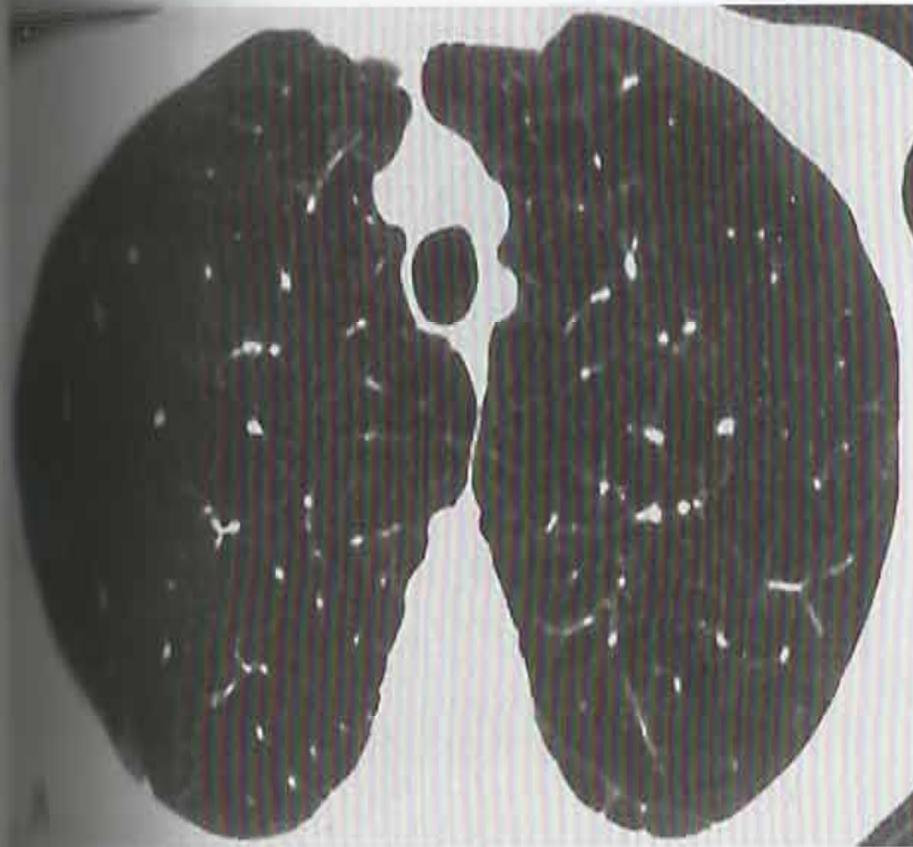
Panlobular emphysema in two patients. A: On HRCT, lung volumes are increased, the lungs appear lucent, and the size of pulmonary vessels is decreased. Focal lucencies, as seen in patients with CLE, are not visible. B: Panlobular emphysema in a patient who has had a right lung transplantation. The right lung is normal in appearance and attenuation. The emphysematous left lung is abnormally lucent, increased in volume, and contains fewer and smaller visible vessels.
